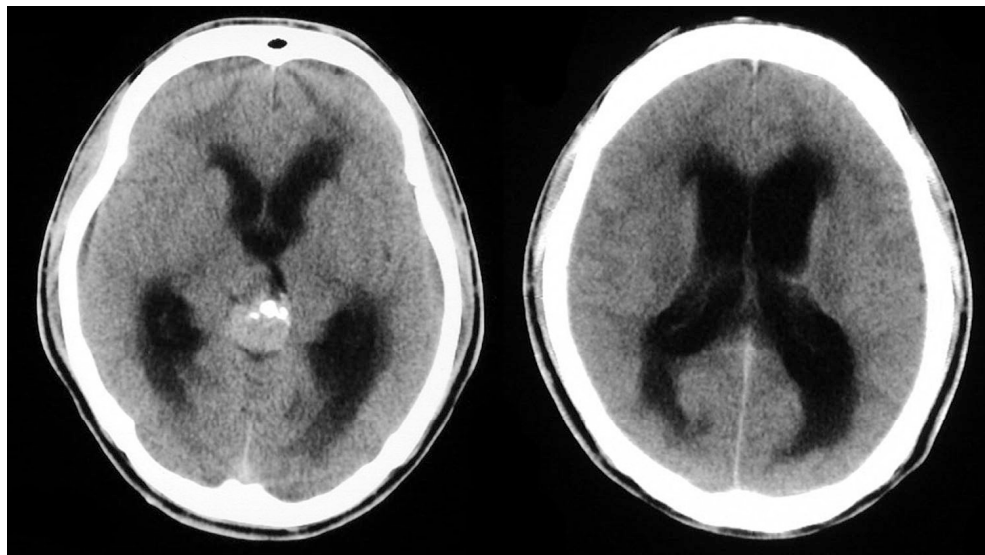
Computed tomography (CT) scans of a pineal germinoma on admission. Marked hydrocephalus is evident together with the pineal mass.
